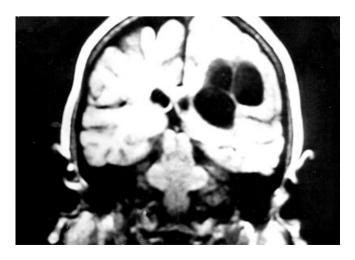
Magnetic resonance imaging, showing a clump of three large cysts producing a space-occupying lesion
